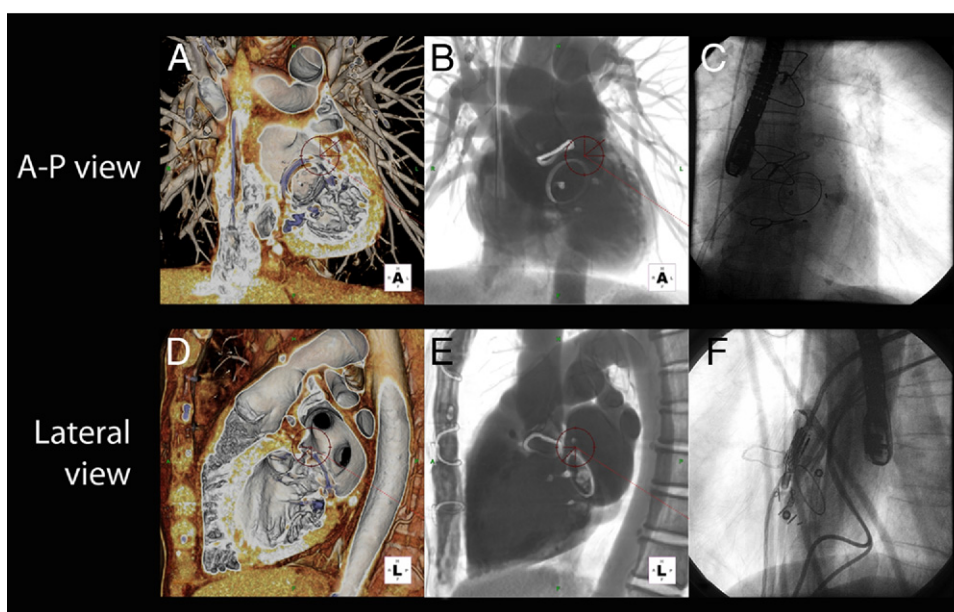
3D CTA Guidance During Paravalvular Leak Closure Procedure
